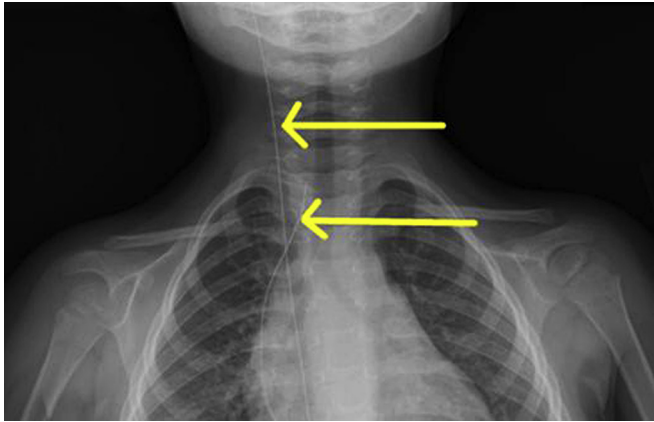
Radiograph of a guidewire unintentionally retained during central venous catheterization. Reprinted with permission.
